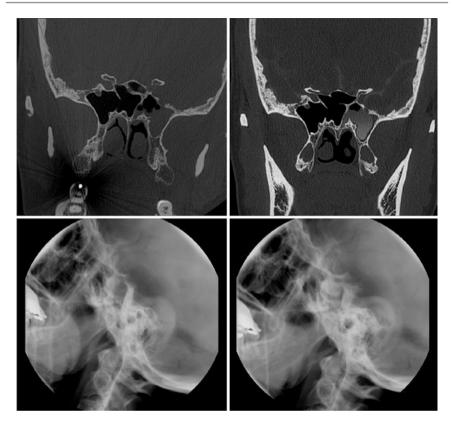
High-resolution computed tomography (CT) of the skull base shows dehiscence at the foramen rotundum and fluid in the involved sphenoid sinus. The addition of intrathecal contrast shows contrast entering the sphenoid sinus on CT and plain films, confirming the communication with the subarachnoid space
